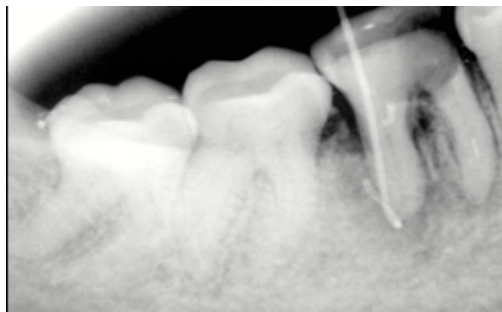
Radiograph showing sinus tracing
